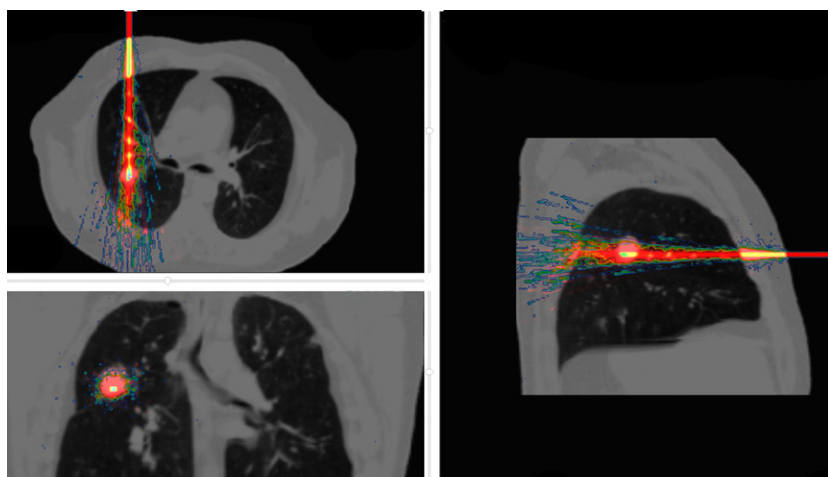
Dose deposited by a carbon ion beam inside a CT image of a thorax. The colour scale is a warm metal scale, with high values (white) corresponding to high-dose deposit and low values (blue) corresponding to low-dose deposit.
